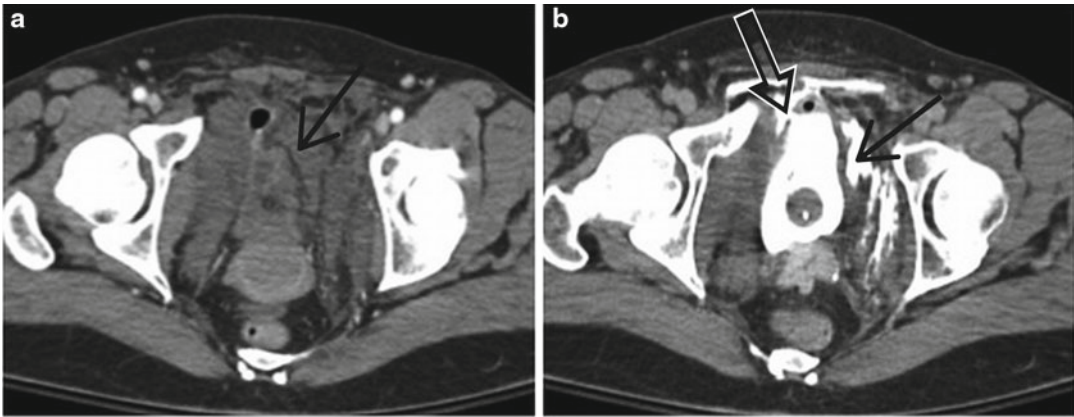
CT cystography of an extraperitoneal bladder injury. (a) Note free fluid in the pelvis and space of Retzius (arrow) on the noncontrast CT. (b) Note contrast leak into
